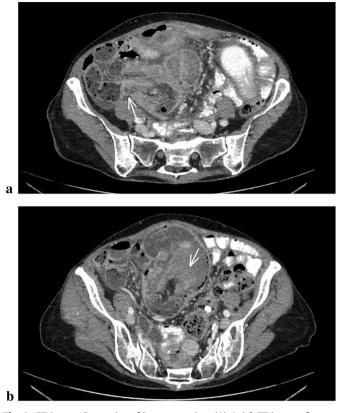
CT Images Suggestive of Intussusception. (A) Axial CT image of an apparent small bowel transition point in the right lower quadrant (indicated with white arrow). (B) Axial CT image demonstrating abdominal mesenteric fat prolapsing into the cecum (indicated with white arrow). The prolapsed mesenteric fat and colon was seen in subsequent sections extending to the level of the transverse colon.
